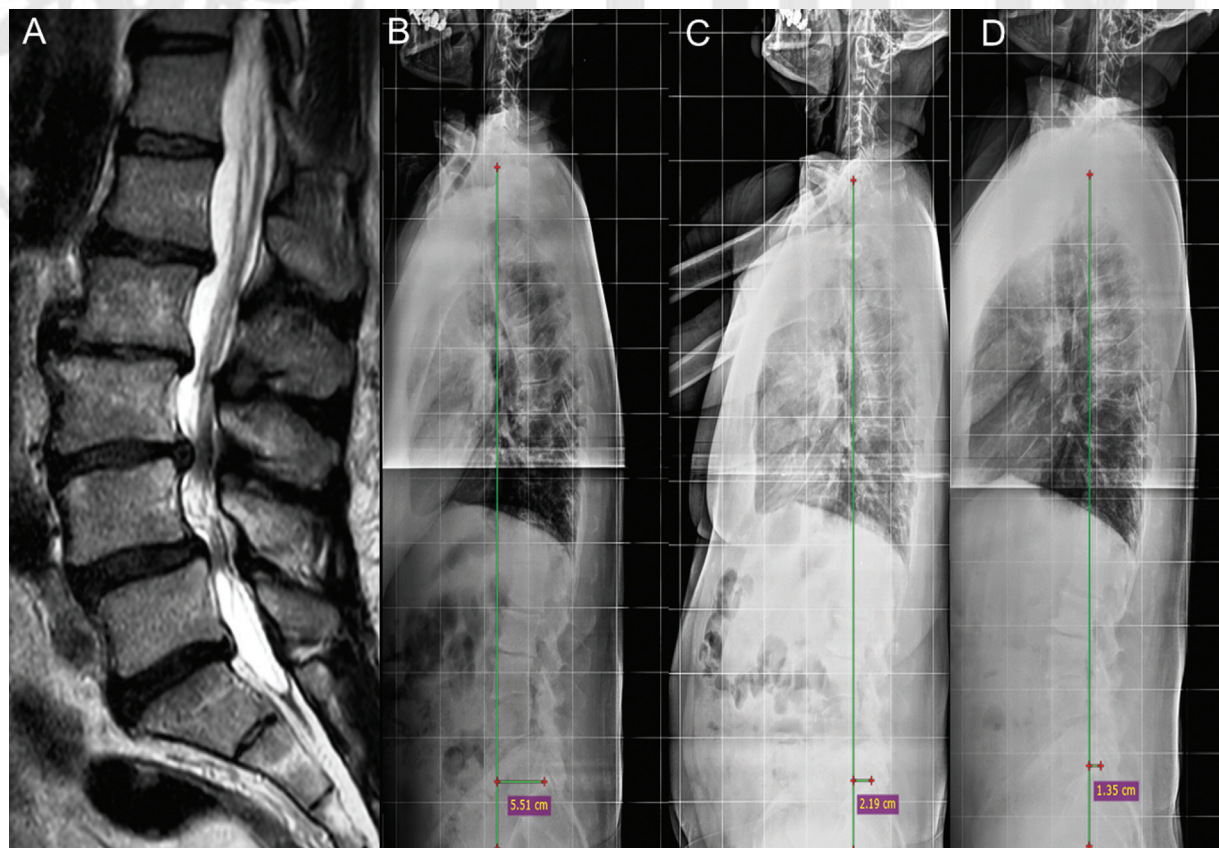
(A) Preoperative T2-weighted lumbar sagittal magnetic resonance imaging (MRI) of a 59-year-old man with a lumbar spinal stenosis at the L3–L4 and L4–L5 levels. (B) Preoperative and (C) 6-month and (D) 24-month follow-up full-body X-ray showing a progressive decrease of sagittal vertical axis (SVA) from 5.51 to 1.35 cm after minimally invasive decompression (MID).
